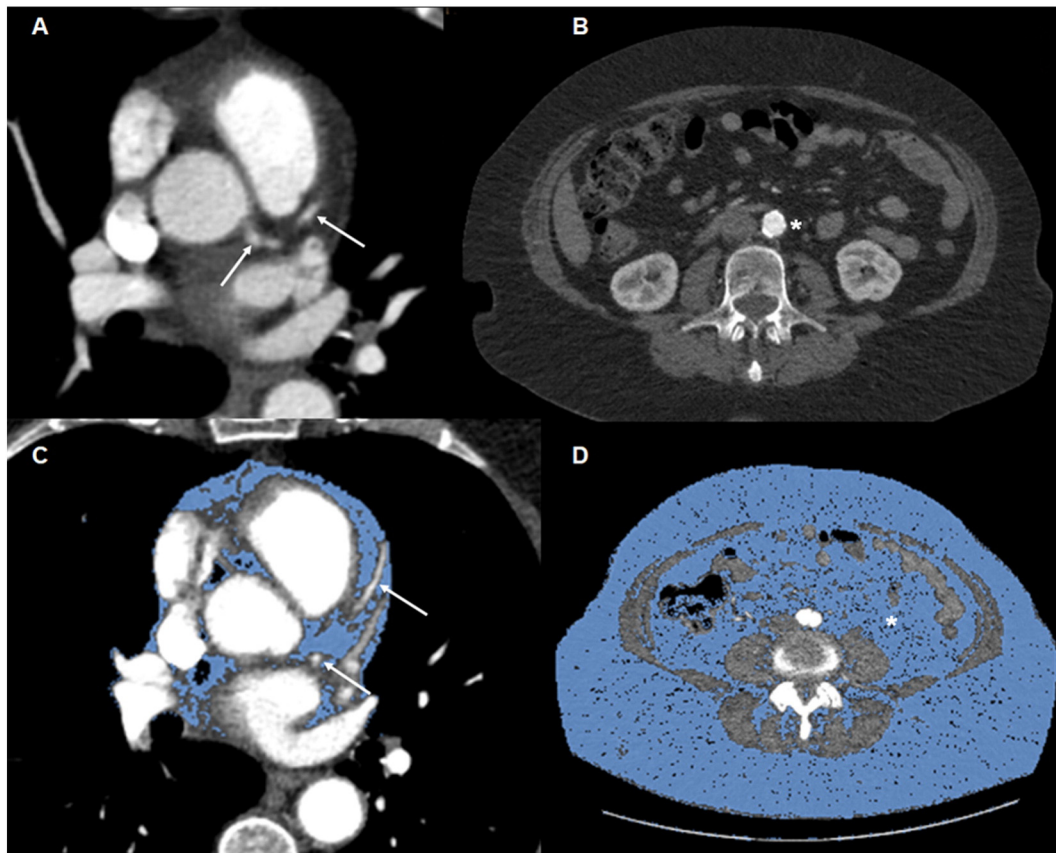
Obese female, with large subcutaneous fat accumulation and no evidence of coronary disease. Seventy year-old female, CTA indicated due to ascending aorta dilatation. She has multiple coronary risk factors (hypertension, hypercholesterolemia, smoking) and a BMI of 31.2 kg/m². No evidence of coronary atherosclerosis is detected (SIS 0, arrows in panels A and C). Extra-coronary SS was 11.0 (* in panel B). Total body FV was 12,390 cm³/m² (above the 75% percentile). Pericardial FV was 84 cm³/m² (below median) and abdominal FV (blue, in panel D) was 8518 cm³/m² (above the 75% percentile), of which only 32% was visceral fat (*, in panel D).
